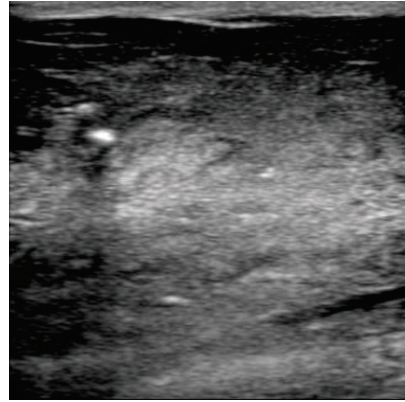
Ultrasonographic view of fibrosed udder
